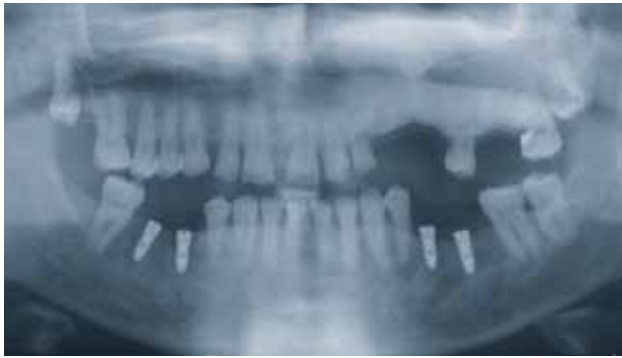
Orthopantomography before implant placement showing high density bone in 2.4 area.
